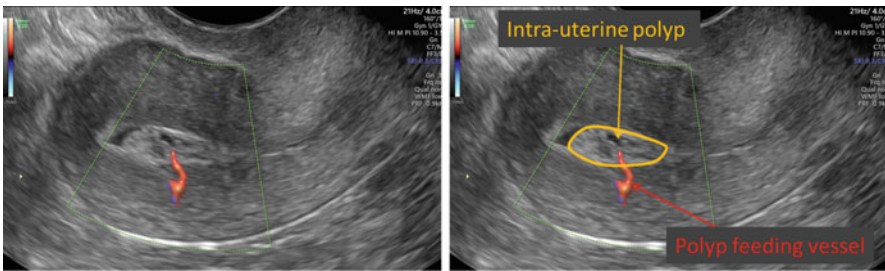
Ultrasound of intra-uterine (endometrial) polyps. Polyps can be distinguished by their hyperechoic appearance that often distorts the endometrial echo. The presence of intra-cavity fluid can help to further solidify the diagnosis of endometrial polyps. An endometrial polyp with a finger-like projection in the cavity is outlined above. Using color Doppler, as many as half of endometrial polyps will demonstrate a solitary feeding vessel
